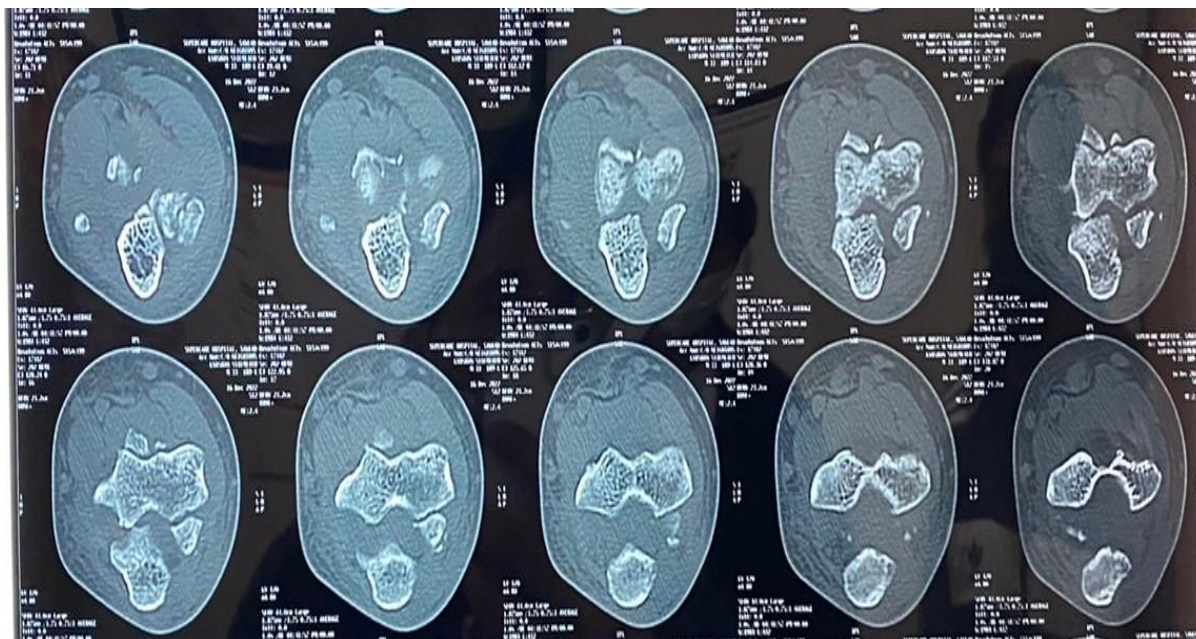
3D CT scan images showing fractures involving radial head, coronoid process, capitellum, trochlea with posteromedial dislocation of elbow
